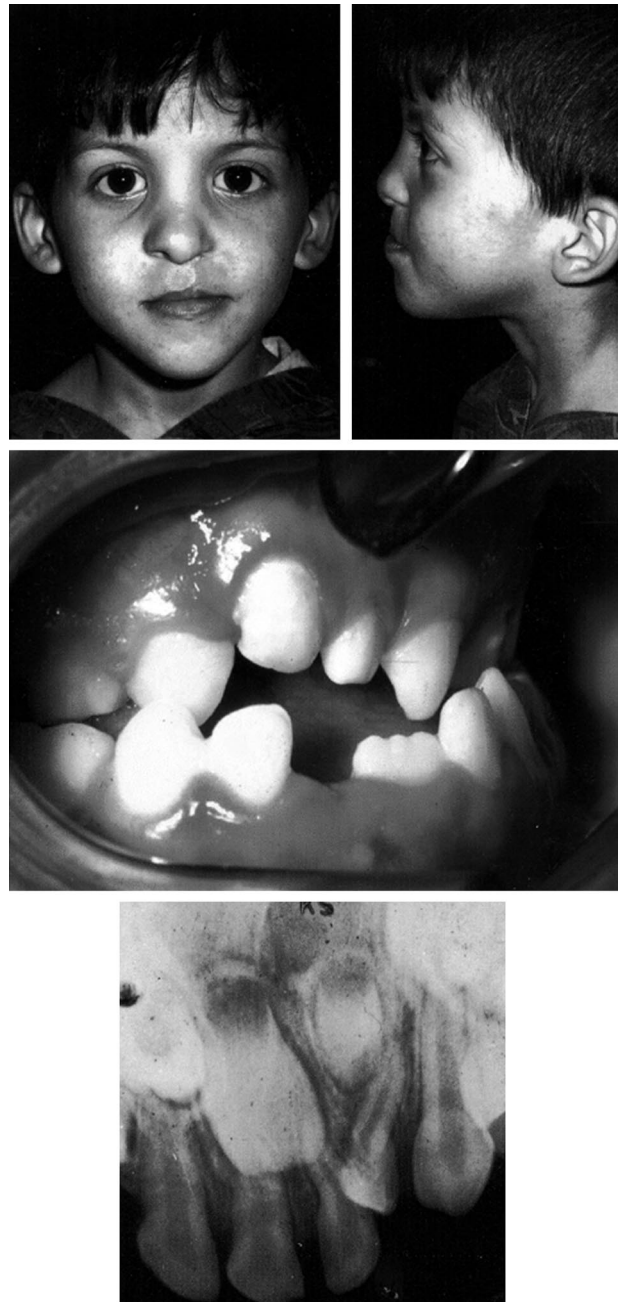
Eight-year-old boy with presurgical orthopedics-treated complete unilateral cleft lip and palate. (Above) Facial photographs show midfacial recessiveness caused by retruding the premaxillary portion of the larger segment. In some cases, the resulting anterior crossbite is correctable in the permanent dentition only after extensive use of orthodontic appliances and only if minor bone bridging occurred. (Center) Intraoral photograph shows that the right maxillary lateral incisor space was completely blocked out. The resulting anterior crossbite with an open bite could not be orthodontically corrected in the deciduous dentition. (Below) Periapical radiograph shows the blocked-out right lateral incisor space.
